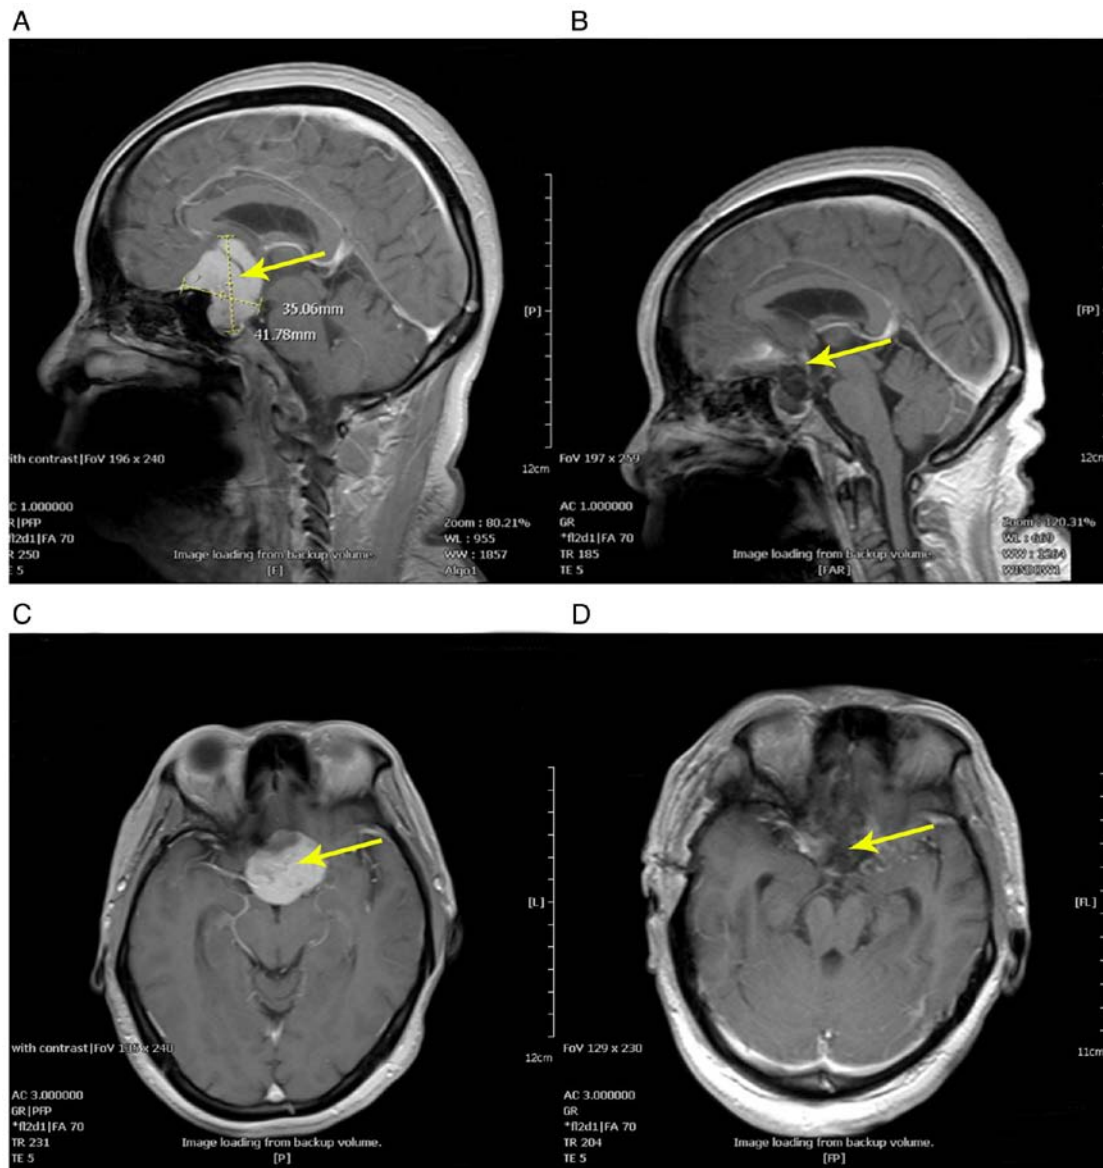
Case 2 of endoscopic supraorbital keyhole approach. Patient 4 is a 51-year-old female with decreased vision and headache. (A) Sagittal image of the preoperative MRI, showing an intrasellar tumorous lesion with a maximum diameter of 41.78 mm. (B) Sagittal image of the postoperative MRI, showing no remnant tumor tissue. (C) Axial image of the preoperative MRI. (D) Axial image of the postoperative MRI. The yellow arrow indicates the tumor or the tumor cavity.
